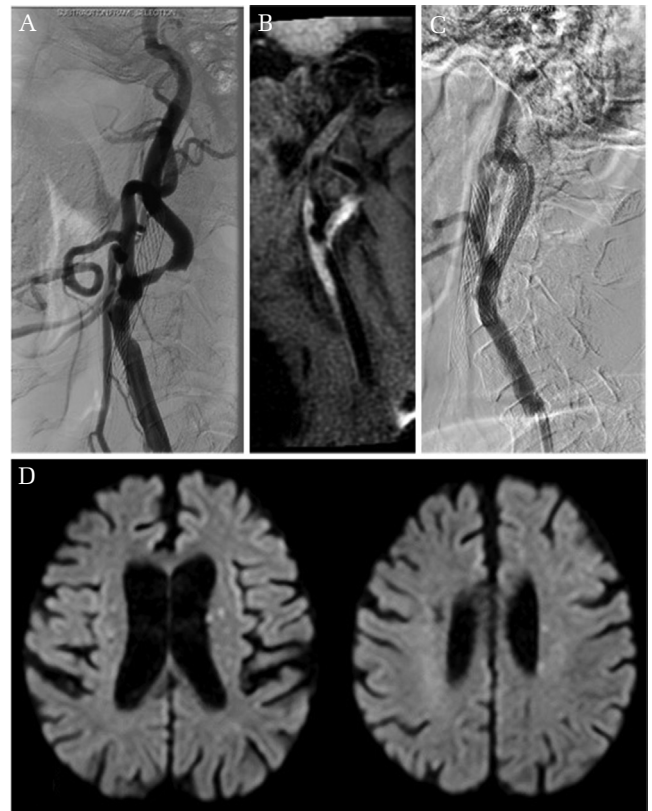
Case 2: (A) Preoperative angiography reveals severe stenosis in the left internal carotid artery. (B) Preoperative carotid plaque imaging by MRI shows unstable plaque. (C) Carotid artery stenting was performed using filter protection under local anesthesia. During the procedure, disturbance of consciousness and conjugate deviation of the eyes to the left were observed. (D) Postoperative MRI reveals multiple cerebral infarctions.
